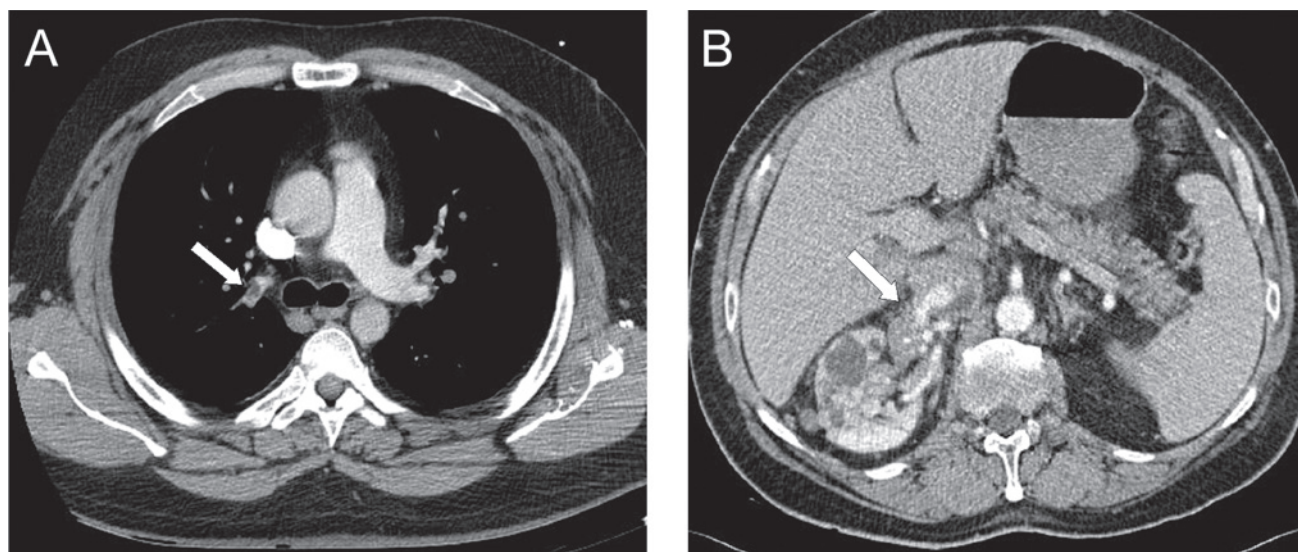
Asymptomatic PE (arrow, A) and renal cell carcinoma (arrow, B) identified with CT scan of chest as part of the evaluation of patients with iliofemoral DVT.²⁹ Used with permission.
